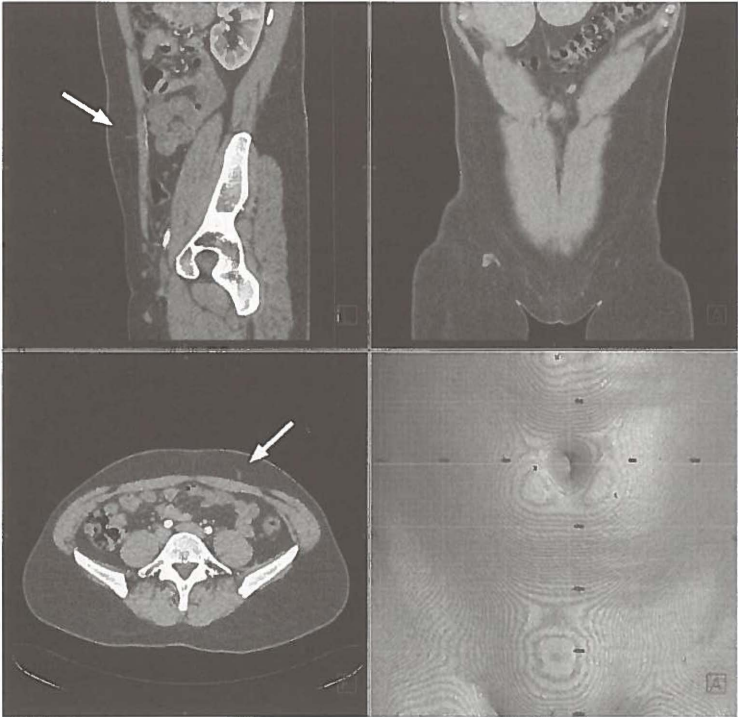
Reconstructions of CTA images in the sagittal, coronal and axial planes, and the VRT coronal image with a grid. The best perforator is marked with an arrow.
